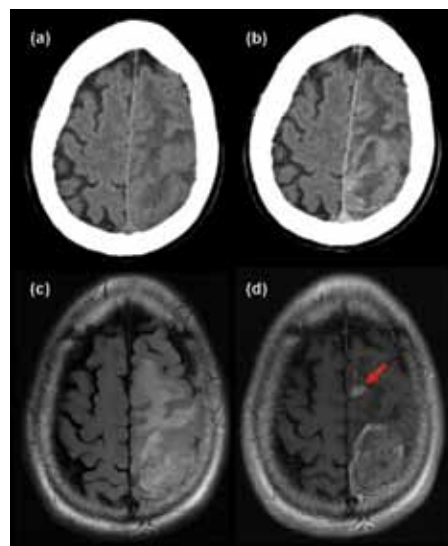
Imaging of a glioblastoma. (a) An unenhanced CT and contrast enhanced CT (b) show the lesion and the oedema. The latter is better identified on the FLAIR imaging (c). Contrast enhanced T1-weighted imaging shows a small focus of enhancement separate from the main body of the tumour that was not identified by other methods.
